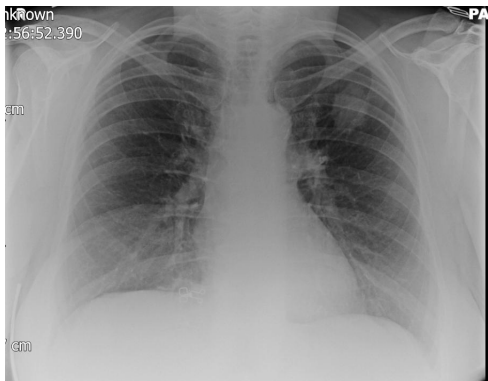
Incidental left upper lobe mass on chest x-ray.
